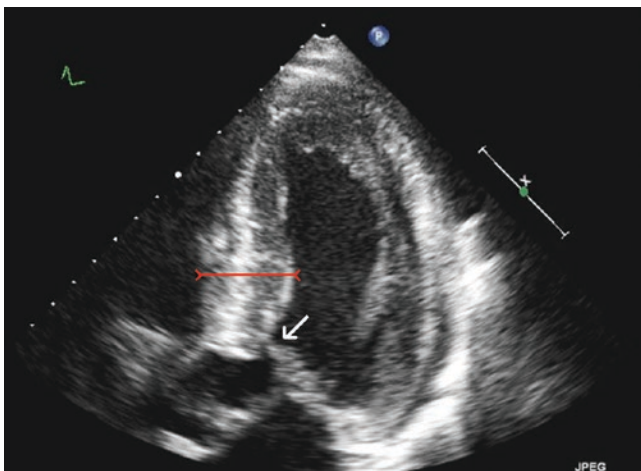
Apical four chamber echocardiography in a HCM patient. Red arrow indicates the hypertrophic interventricular septum (>25 mm), and the white arrow indicates systolic anterior motion of a mitral valve leaflet in the left ventricular outflow tract
